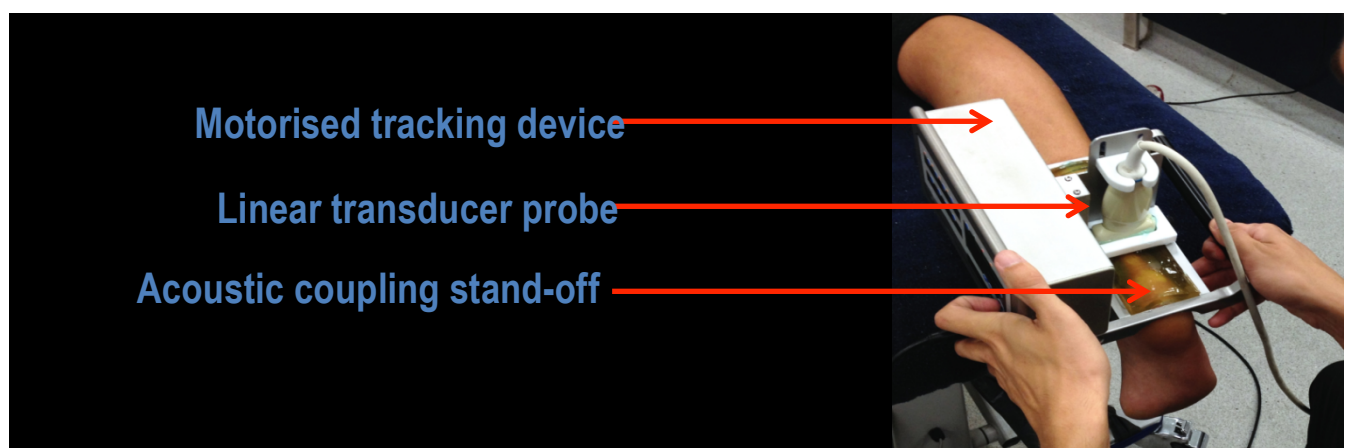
Ultrasound tissue characterisation tracking unit
